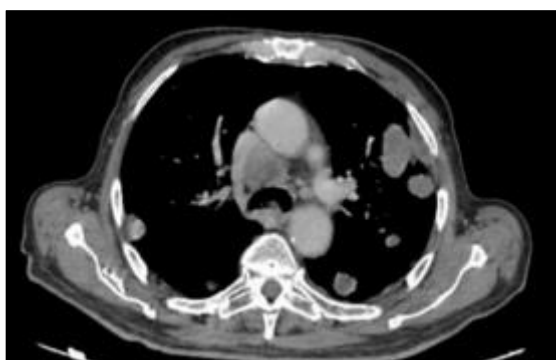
CT scan showing multiple pulmonary metastatic nodules.
